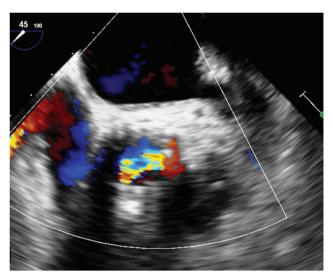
Preoperative transesophageal echocardiography revealed severe AR and prolapse of the TAV leaflet, similar to the left coronary cusp. AR: aortic regurgitation; TAV: transcatheter aortic valve
